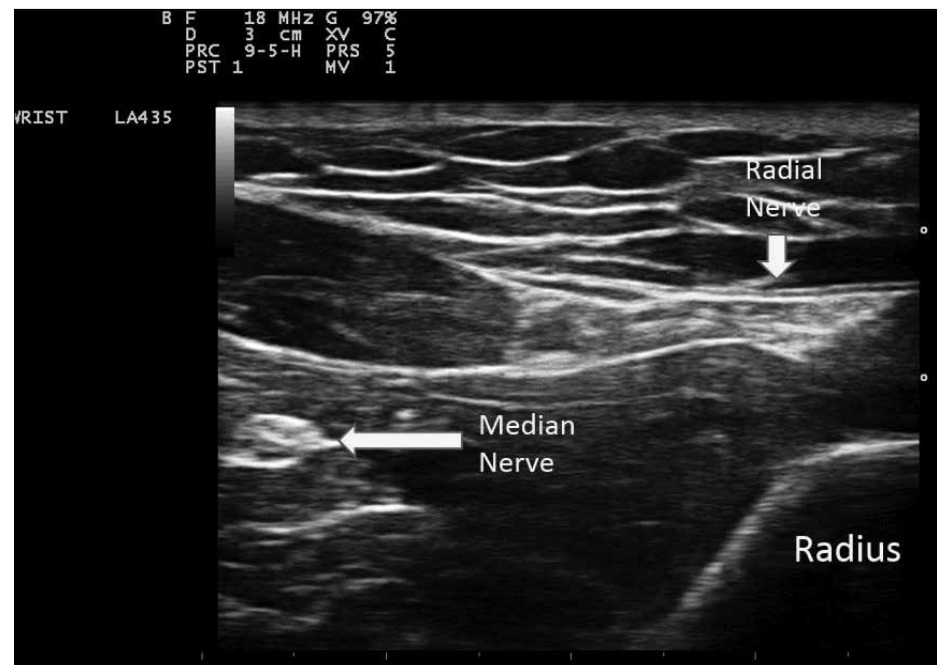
Simultaneous visualization of the radial and median nerves on an ultrasound screen.
